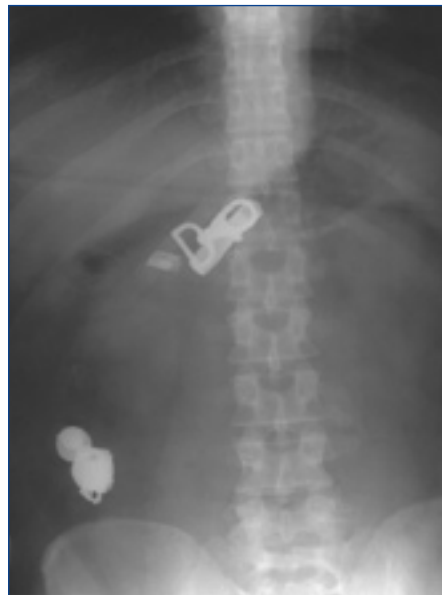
X-ray showing ingested objects in the duodenum and ileocaecum (case report 1).
